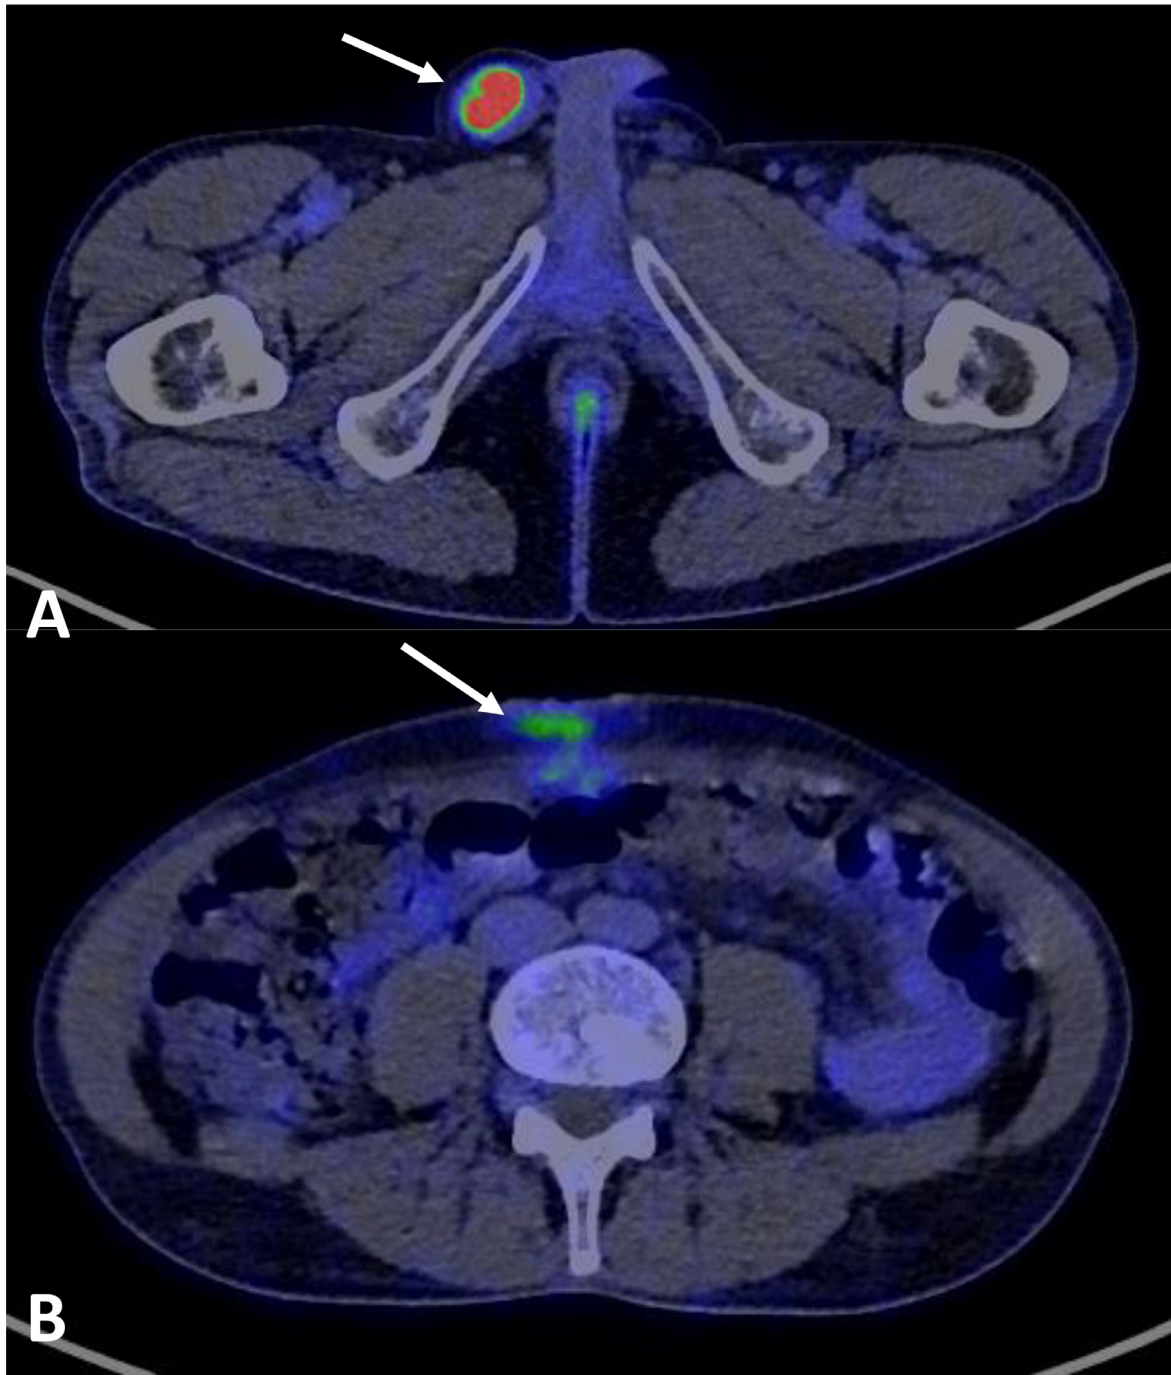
Axial reconstruction of FDG PET-CT. (A) Markedly increased tracer uptake within the right inguinal paratesticular soft tissue. (B) Mild to moderate tracer uptake in the soft tissues at the site of the excised umbilical lesion.
